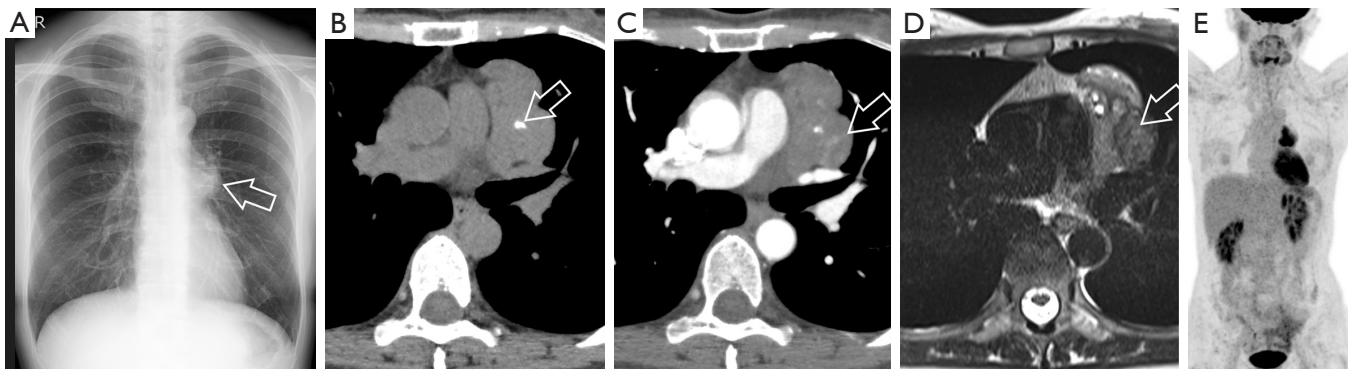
Case 1: a female in her forties was incidentally identified with abnormalities during a health check-up, with no elevated tumor markers. (A) Chest X-ray; (B) plain CT (axial); (C) contrast-enhanced CT (axial); (D) T2WI (axial); (E) FDG-PET (MIP). Chest X-ray revealed a protruding mediastinal mass on the left side with the hilum overlay sign (A, arrow). A plain CT showed calcifications (B, arrow). A contrast-enhanced CT showed intratumoral septal enhancement (C, arrow). A low signal septum was seen in the same location on T2-weighted MRI (D, arrow). FDG-PET/CT revealed intense FDG uptake. CT, computed tomography; T2WI, T2-weighted images; FDG, fluorodeoxyglucose; PET, positron emission tomography; MIP, maximum intensity projection; MRI, magnetic resonance imaging.
